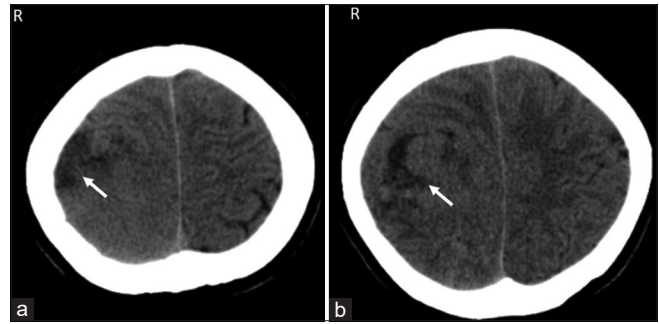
(a and b) Axial head computed tomography scan revealing heterogeneous mass starting from the right parietal region and extending toward the midline, brain parenchyma has been pushed, and the mass causes compression in the lateral ventricle
